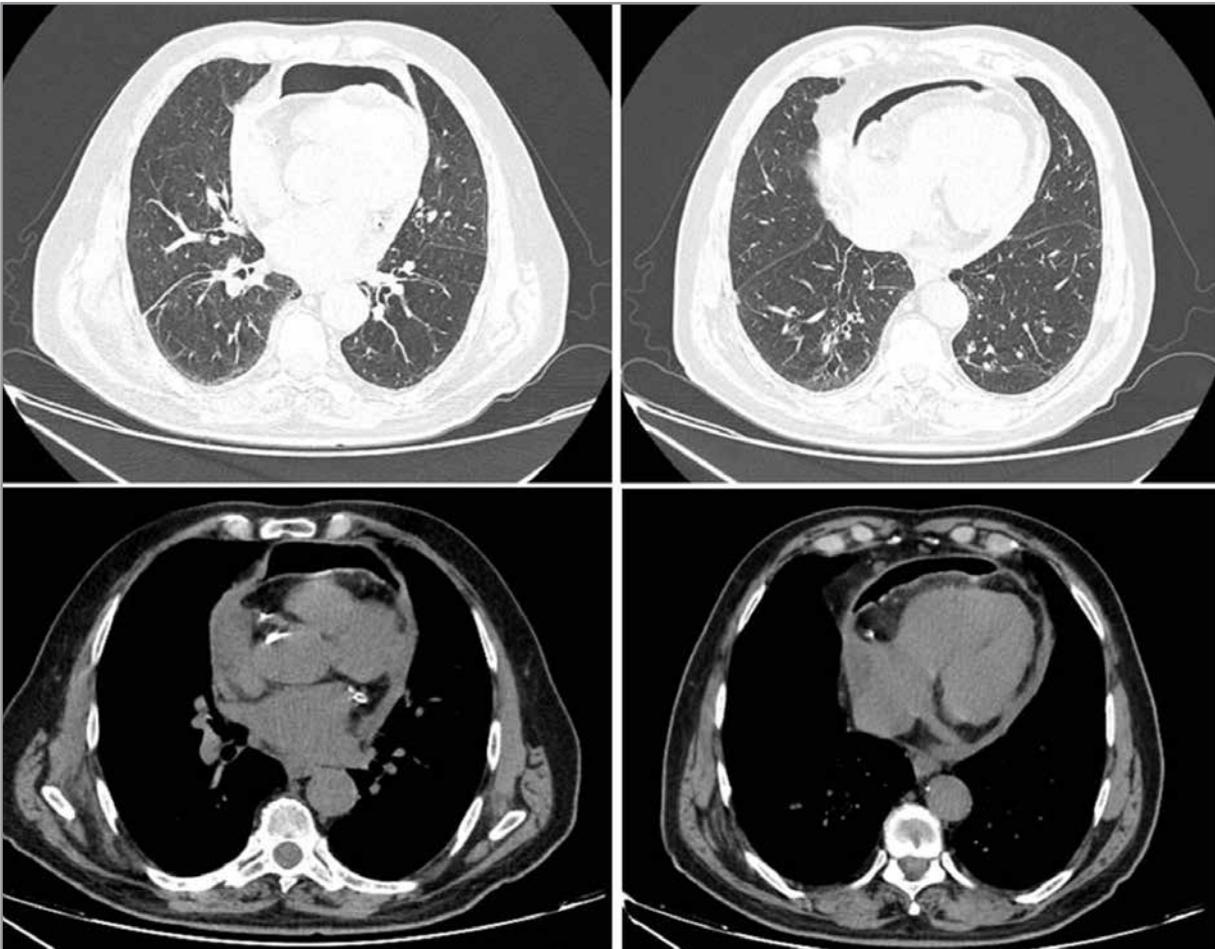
Computed tomography showed 2 cm pericardial effusion and air in the pericardial space.
